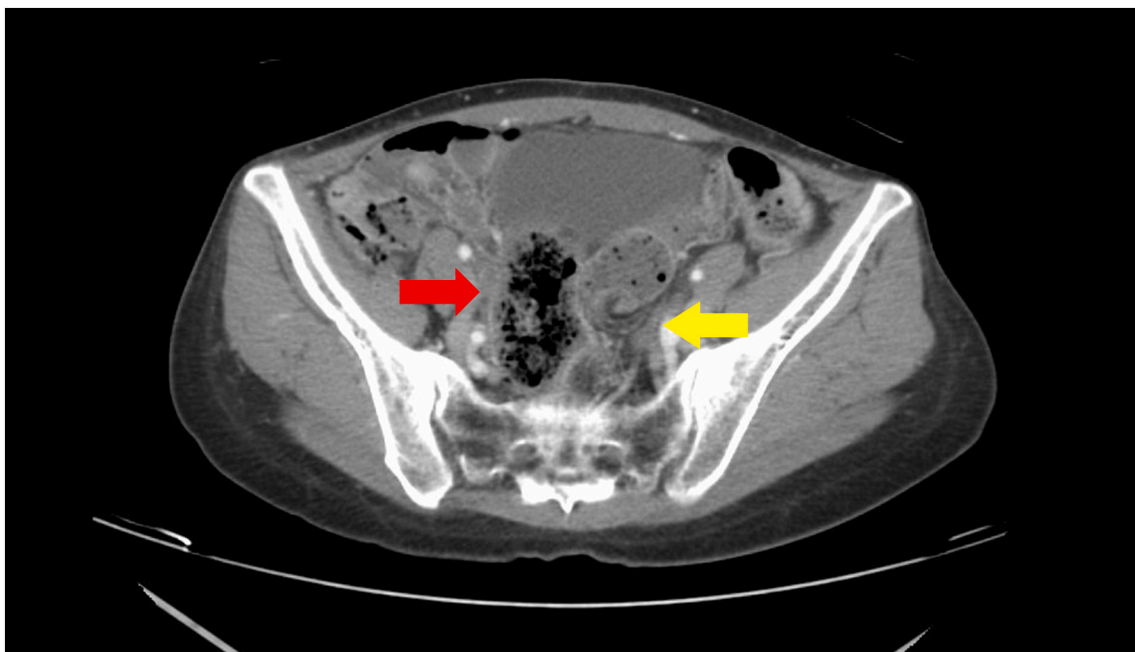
Contrast CT shows closed loop obstruction of sigmoid colon (yellow arrow).
